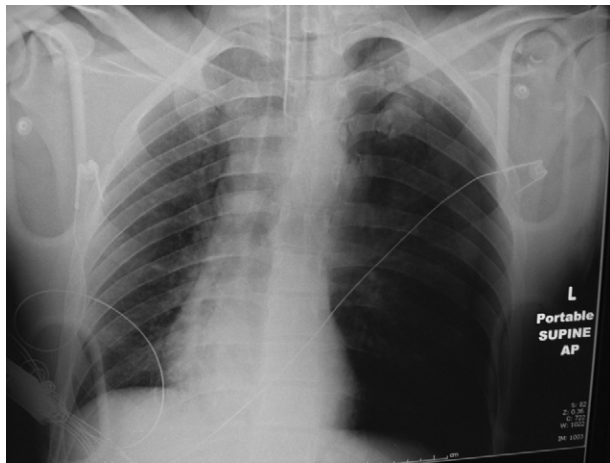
Tension pneumothorax. Hyperlucency is noted, mostly toward the left lung base, because the x-ray is a supine exposure. Shift of the mediastinum toward the right is noted. (From Marx JA, et al, eds. *Rosen's Emergency Medicine: Concepts and Clinical Practice*. 7th ed. Philadelphia: Mosby; 2010:394.)
